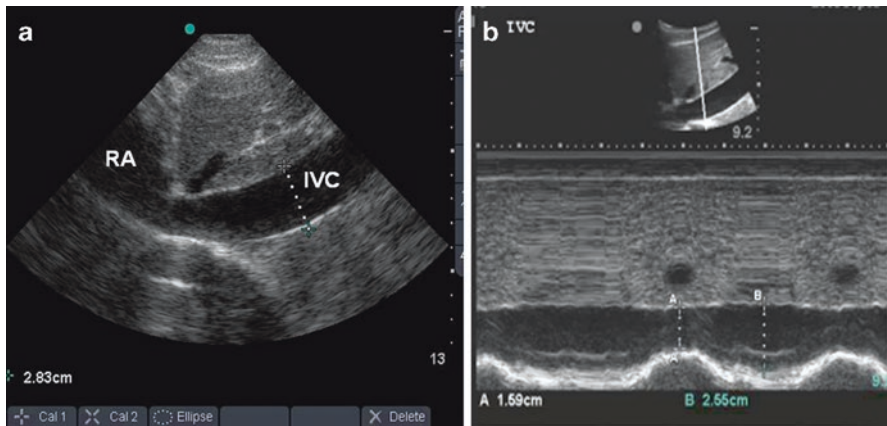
Ultrasound evaluation of the inferior vena cava for volume assessment. (a) The inferior vena cava (IVC) is demonstrated as it enters the right atrium (RA) in longitudinal section, and the measurement of 2.8 cm suggests adequate intravascular volume. (b) M-mode evaluation of the vena cava is used to compare the diameter at inspiration (A) to that at expiration (B). Note that this vessel shows less than 50% collapse, again indicating adequate intravascular volume status
